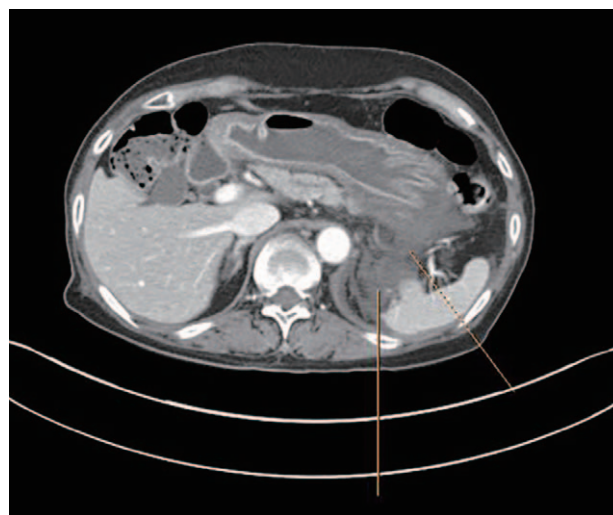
Abdomen computed tomography scans showed a perigastric fluid collection in accordance with a perforation of the stomach (between lines).
